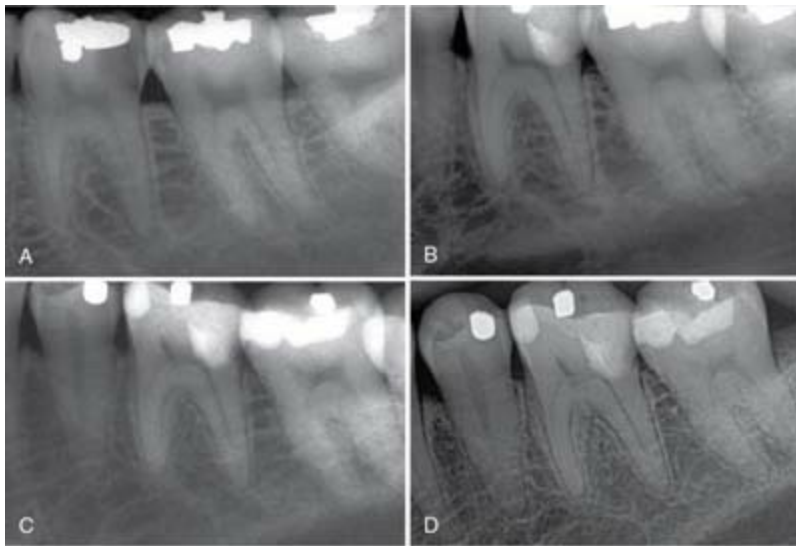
A, Periapical radiograph of deep caries in a partially symptomatic mandibular left first molar in a 29-year-old female patient. B, Direct pulp capping completed with white mineral trioxide aggregate (MTA); the final bonded restoration was placed during the second visit after MTA curing. C, Radiographic recall at 7 years. Tooth was asymptomatic with normal response to CO₂ ice. D, Thirteen-year 10-month recall radiograph showing normal periapical appearance. The molar responded positive to cold testing and demonstrated normal mobility and periodontal probings.
